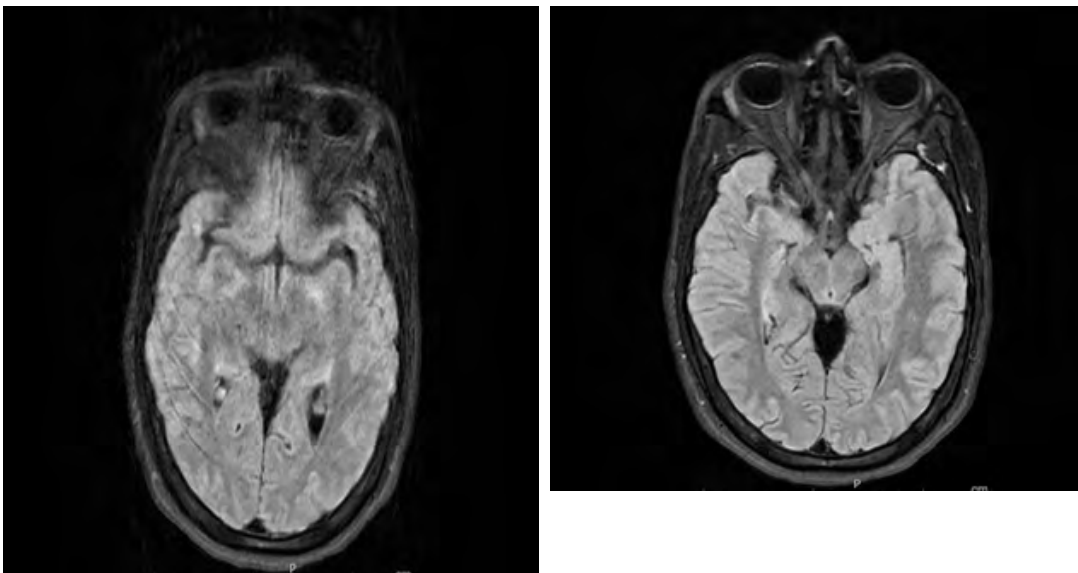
MRI with bilateral hippocampal signal on T2 flair
